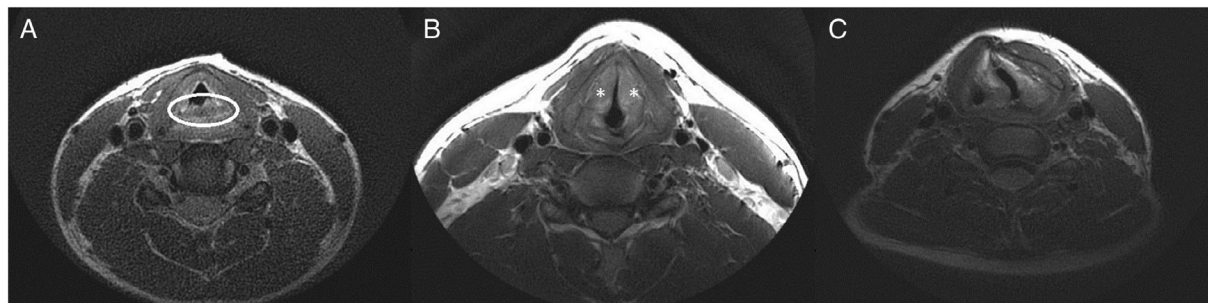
Example of the magnetic resonance imaging analysis of the static images showing (A) arytenoid prolapse, (B) vocal cord thickening, and (C) vocal cord deviation.
